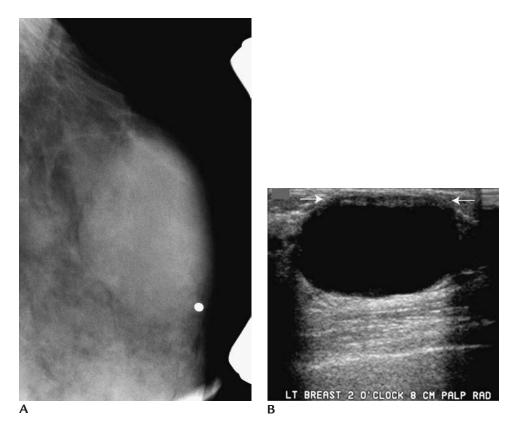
Cyst. (A) Spot compression tangential view of palpable finding (metallic BB) confirms the presence of an oval mass with partially circumscribed margins. (B) Anechoic oval mass with circumscribed margins and posterior acoustic enhancement is imaged corresponding to the palpable finding. Near field reverberation artifact (arrows) is noted. Aspiration is not undertaken unless the patient is symptomatic (tender), specifically requests it or atypical features are imaged sonographically.
